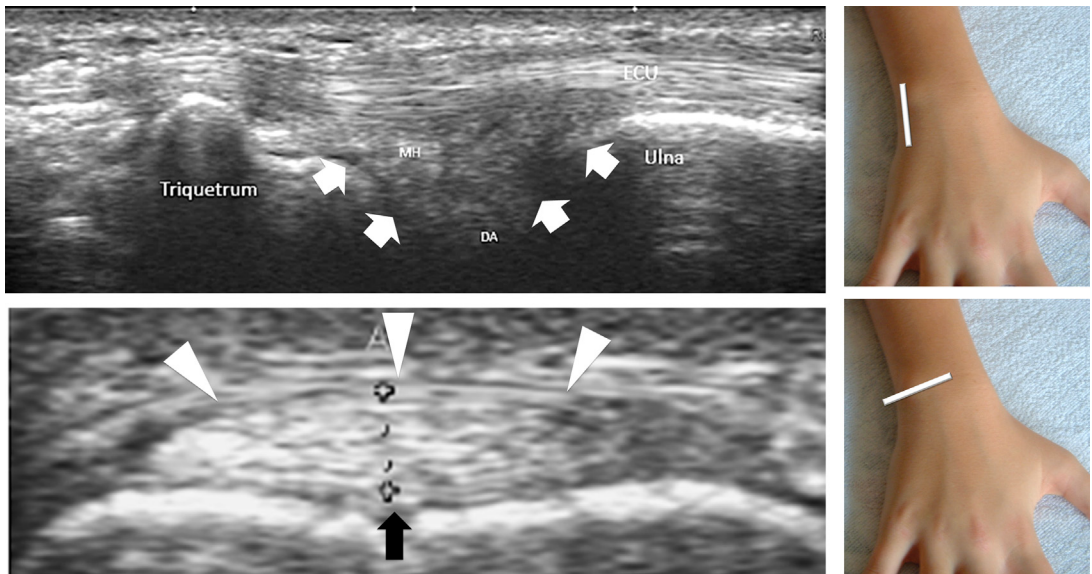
At the ulnar side of the wrist, the triangular fibrocartilage complex is located between the ulnar styloid and distal radius (*white arrows*). The complex is composed of the triangular biconcave fibrocartilage, meniscus homologue, ulnar collateral ligament, radioulnar ligaments, and sheath (*arrowheads*) of the ECU (*black arrow*). Even with high-resolution transducers, US cannot distinguish the different components of the triangular fibrocartilage complex. Their accurate evaluation requires other modalities such as MRI or computed tomography with arthrography. DA, deep arterial arch; ECU, extensor carpi ulnaris; MH, meniscus homologue.
